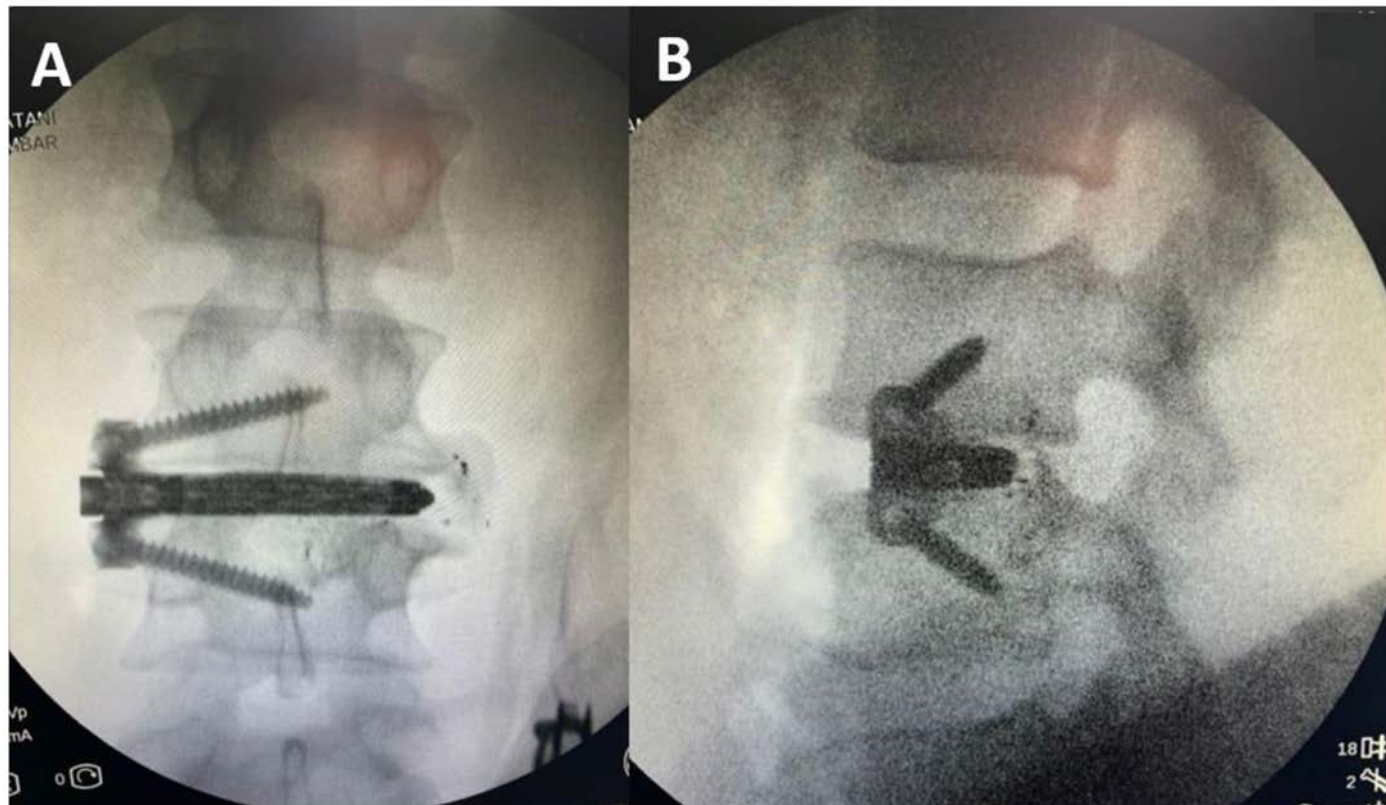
Post-operative radiographic images demonstrating cage position and spinal alignment - Placeholder for image insertion.
